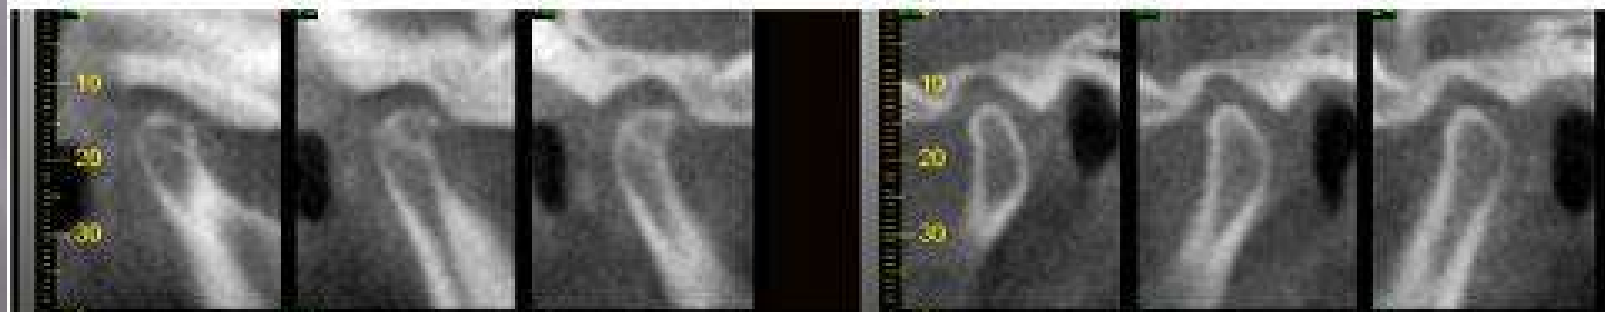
CBCT showing TMJ; Bilateral oblique MPR through lateral and medial poles of the condyle on the axial image showing coronal (B), sagittal view (C) and IVR (D) with right side showing bifid condyle (yellow arrow).
